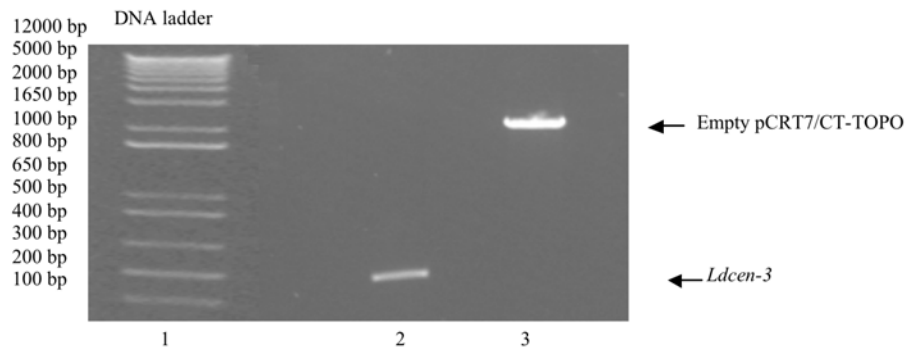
Production of empty pCRT7/CT-TOPO vector.
